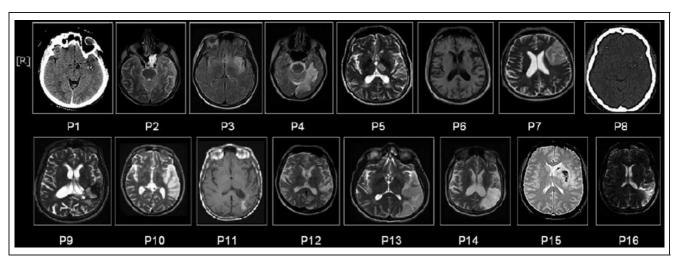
Site of lesion of each patient (MRI or CT scan).
